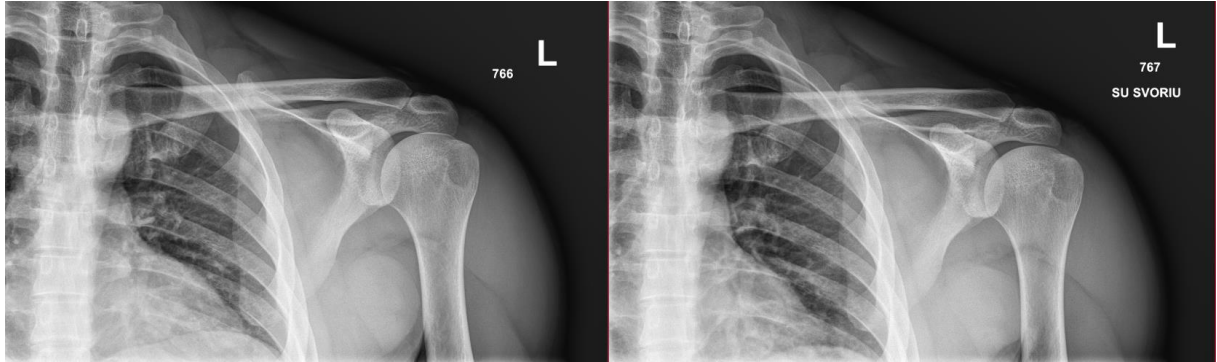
07.12.2021 X-Ray Left Shoulder
